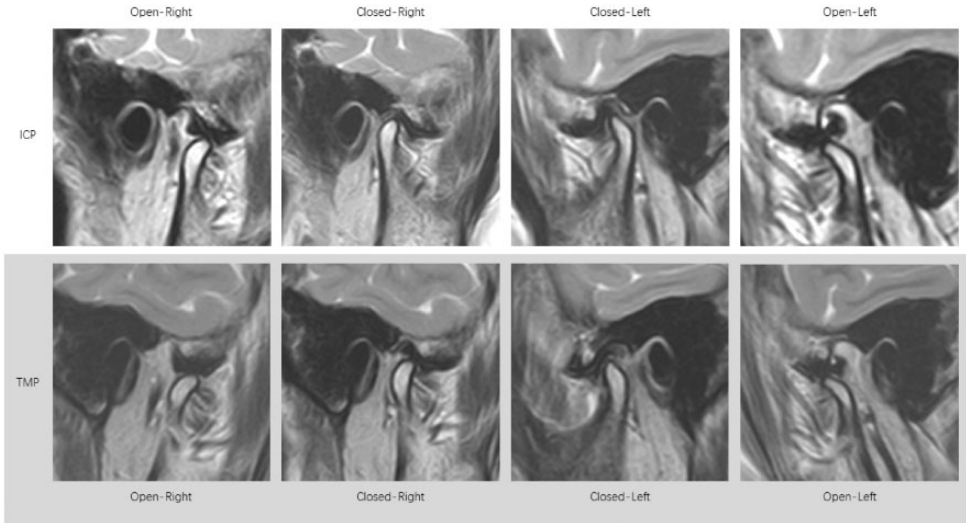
The second magnetic resonance imaging scan showed an improved disc–condyle relationship in the treatment mandible position compared with the intercuspatation position.
